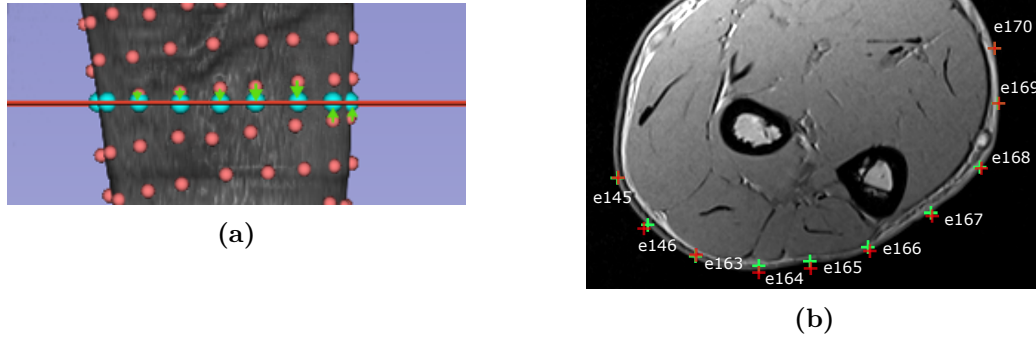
(a) The projection of the electrodes closest to the selected slice plane. The real electrodes position is indicated with a red sphere, the MRI plane is indicated with a red line and the projected position is indicated with a light blue sphere. The projection is depicted with a green arrow. (b) Section of the MRI with the position and the number of the electrodes. The projection of the electrode 3D position on the 2D slice is represented with a red cross. Such points are further projected on the skin (green cross) to find the closest position on the forearm surface.
